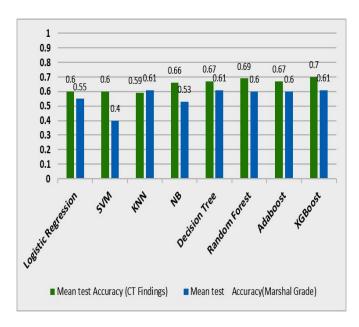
Mean test accuracies in predicting CT Findings and Marshal Grades after a 10 k-fold cross-validation. Models are better at predicting CT Findings than Marshal Grades.
